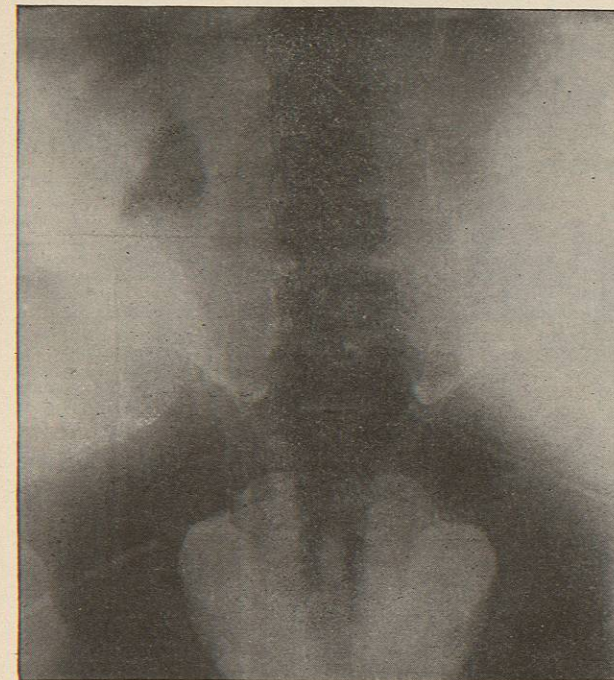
X-Ray Picture of a Renal and a Ureteral Calculus. (From Dr. Alexander B. Johnston's article in the *Annals of Surgery*). In the left kidney there was a large calculus which formed a cast of the dilated pelvis and calyces; in the ureter of the same side there was a stone. The patient, a man forty-one years of age, weighed about one hundred and forty pounds.
